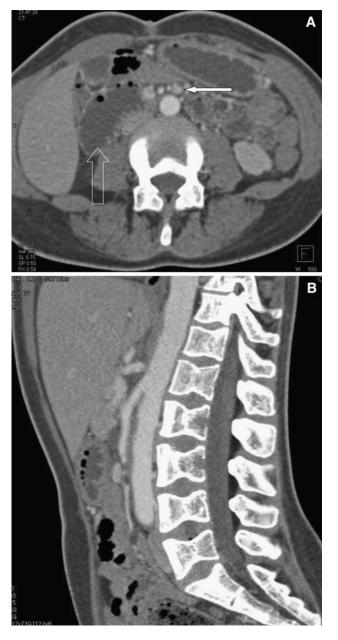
A 26-year-old female with sickle cell disease and chronic abdominal pain, nausea, and vomiting. She was noted to have a dilated proximal duodenum to the level of the SMA on both endoscopy and an upper GI fluoroscopic study. Axial CT image (A) demonstrates a narrowed distance between the aorta and SMA (*arrow*), with dilatation of the proximal duodenum (*open arrow*). Sagittal CT image (B) demonstrates a narrowed aortomesenteric angle. A nuclear medicine gastric emptying study subsequently showed markedly delayed gastric emptying.
